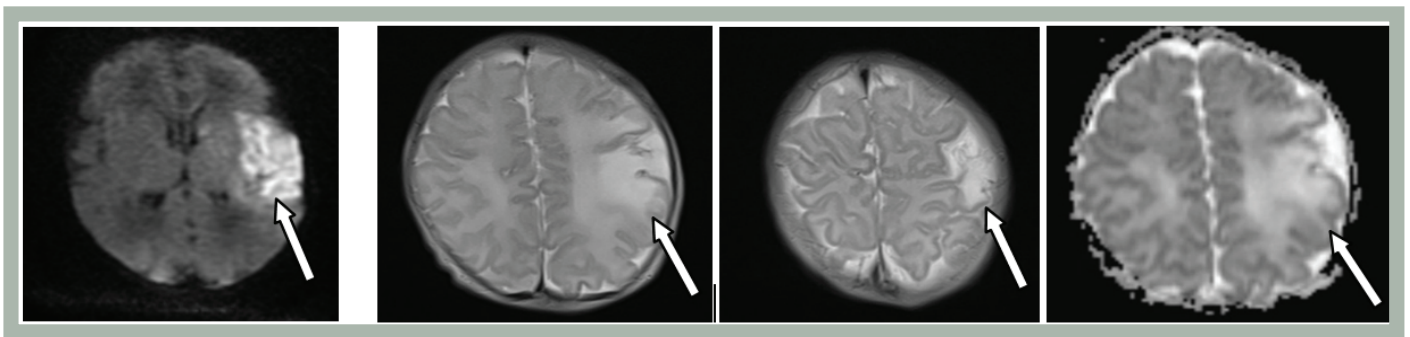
Sagittal T1, transverse T2, T2/FLAIR, T1, susceptibility-weighted imaging, diffusion-weighted images. Brain magnetic resonance imaging showing a thrombus filling the lumen of the right transverse sinus. Haemorrhagic infarct area in the left caudate nucleus, basal ganglia, and left frontoparietotemporal region (left middle cerebral artery territory) with accompanying cortical laminar necrosis
